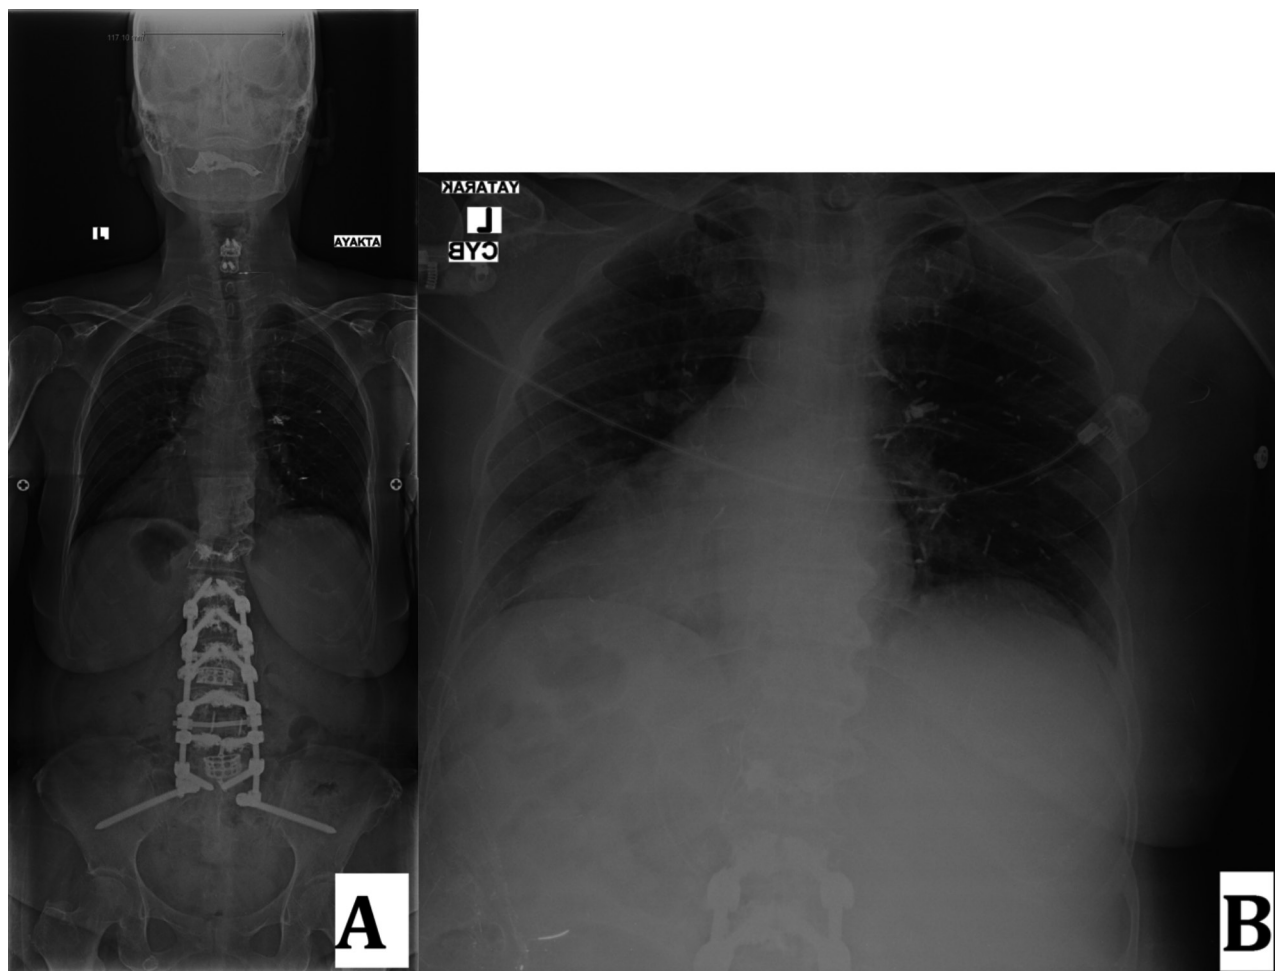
a) Postoperative standing anterior-posterior spine radiograph indicating cement embolism; and b) Postoperative chest radiograph indicating cement embolism
